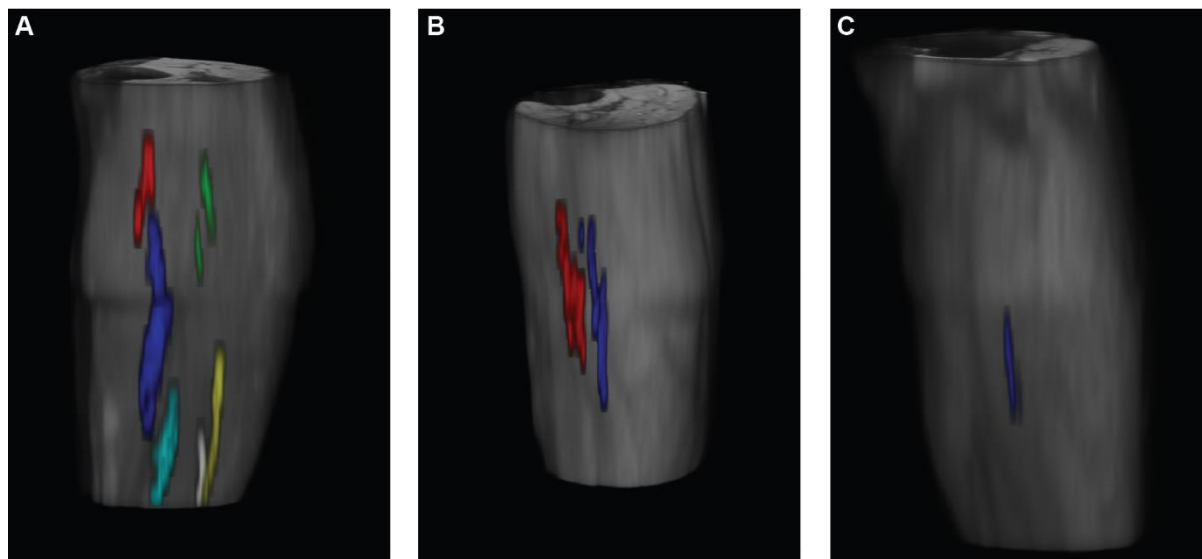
3D motor unit MRI (MUMRI) of single motor units in the lower limbs of healthy volunteers. Liminal electrical stimulation was applied to the common peroneal nerve at the fibular head, and the 3D structure of up to six motor units was reconstructed from multi-slice DWI images sensitive to motor unit contraction. 3D MUMRI reveals a more complex human motor unit structure than previously thought, with several units splitting and re-forming along their length. *Heskamp et al., 2022, available via CC BY 4.0.*
